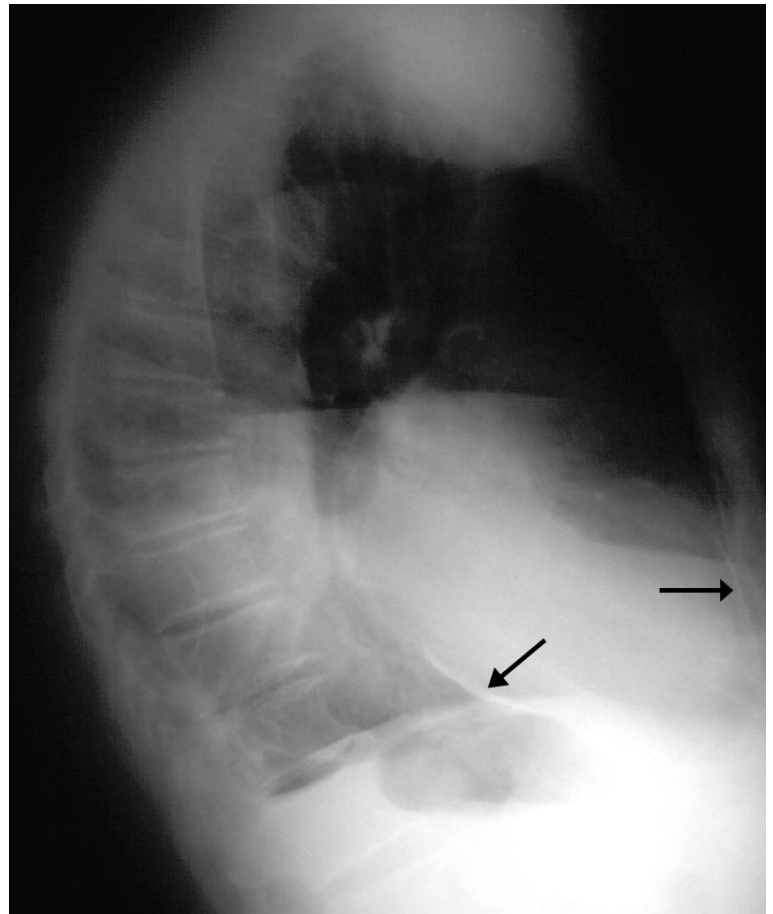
Lateral chest X-ray, showing pericardial calcification anteriorly and posteriorly (arrows).
